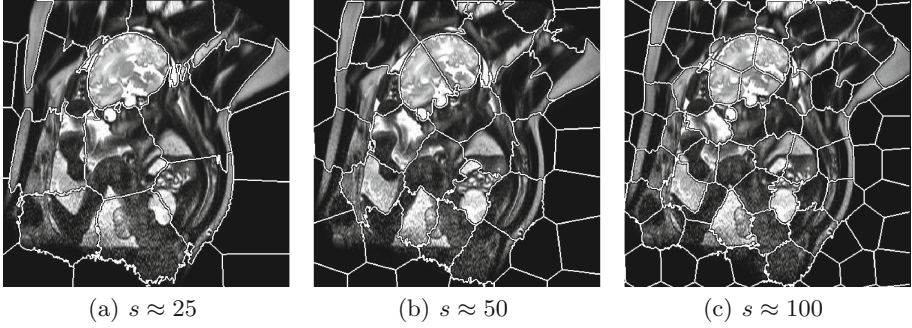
A cropped image of a 2D fetal MRI scan segmented at (a) 25-, (b) 50-, and (c) 100-superpixels.
